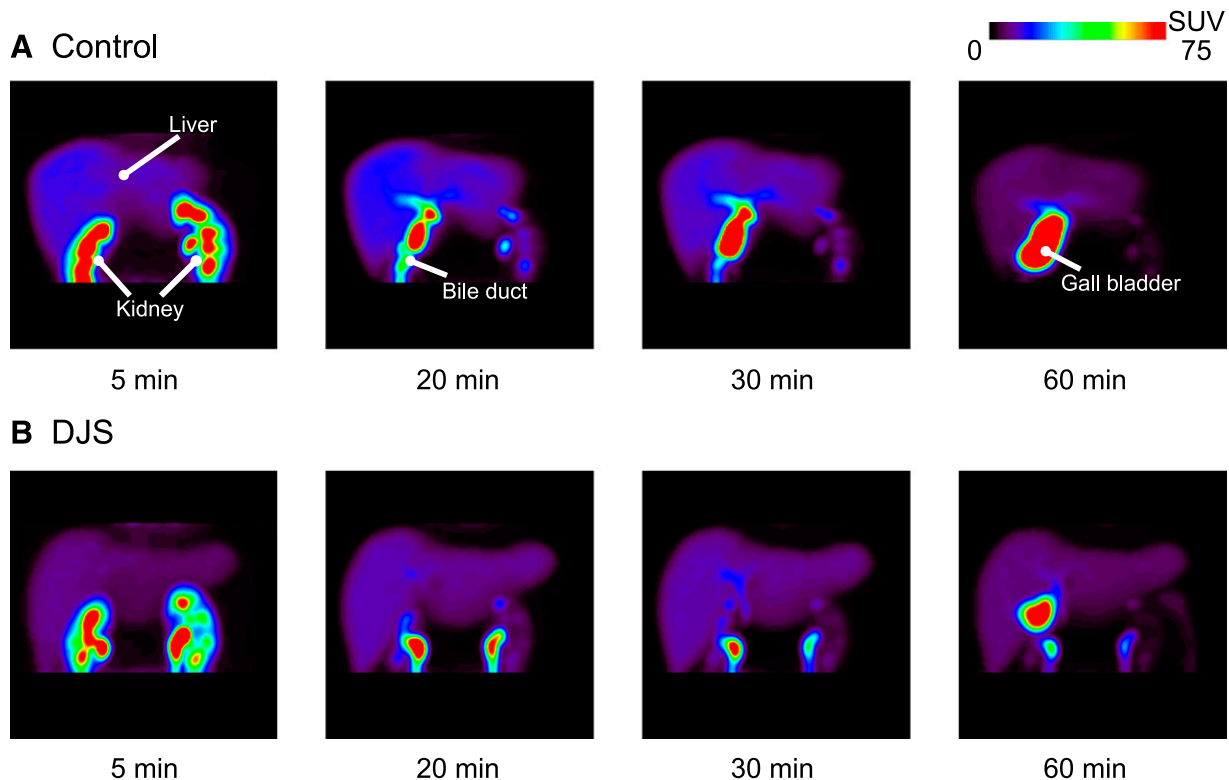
Color-coded PET images of the abdominal region of healthy male subjects (A) and a DJS patient (B) after the administration of [^{11}C]DPV. Coronal maximum-intensity projection PET images of the radioactivity in the abdominal region were captured at 5, 20, 30, and 60 minutes after the administration of [^{11}C]DPV ($82 \pm 12 \text{ MBq}/\text{body}$, $8.7 \pm 5.0 \text{ nmol}/\text{body}$). SUV, standardized uptake value.
